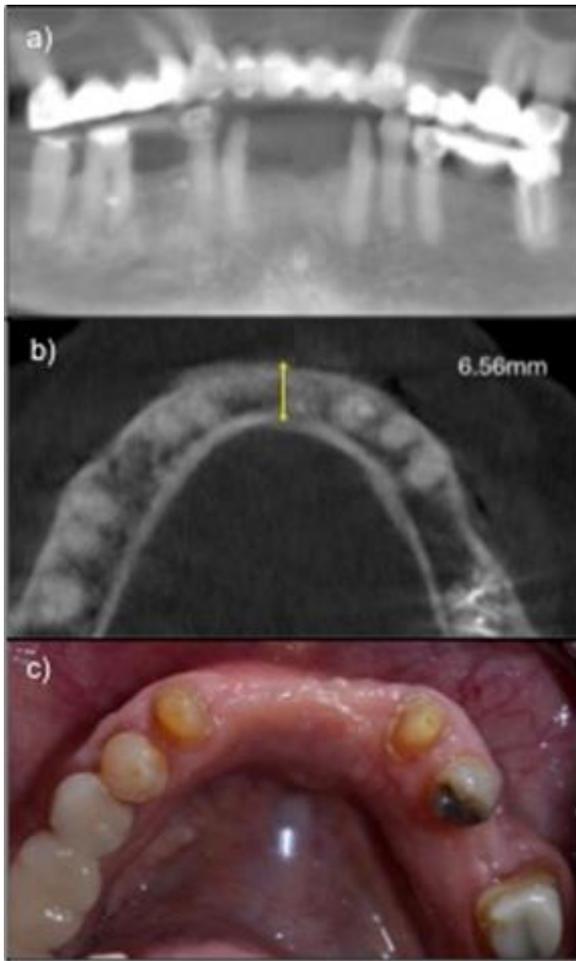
Clinical and imaging results at six months. a) and b) CBCT with a measurement of 6.56 mm in vestibulo-lingual direction. c) Clinical photograph showing an increase of the alveolar ridge with stability of the soft and hard tissues.
